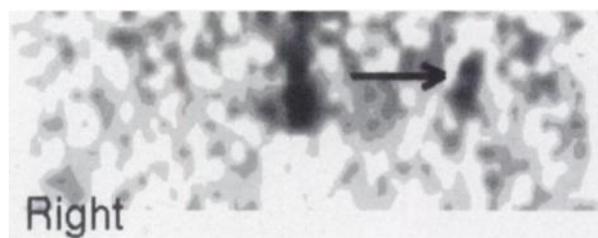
Coronal PET slice shows abnormal FDG uptake (arrow) on left side of inguinal region. Palpable 24-mm lymph node was removed and showed pluriembolic metastases (largest measuring 0.9 mm).
